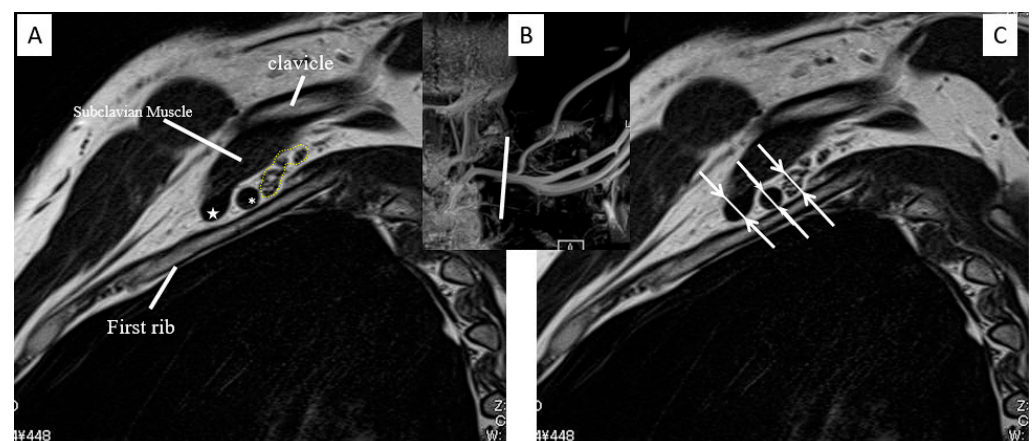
Left sagittal view. (A) The SCV (star), SCA (asterisk), and nerve bundle (dot line) are shown. (B) Scout view of MRI-MIP image. (C) SCA, SCV, and nerve bundle diameter measurements (arrows). MRI-MIP, magnetic resonance imaging maximum-intensity projection; SCA, subclavian artery; SCV, subclavian vein.
